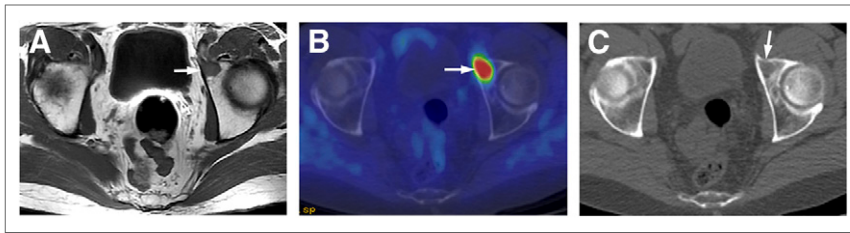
A 68-y-old man with PSA level of 5.0 ng/mL, who underwent RP 3 y earlier and then received salvage external-beam radiotherapy and androgen-deprivation therapy. Results for concordant true-positive MR imaging and ^{11}C -choline PET/CT results with a score for both MR imaging and ^{11}C -choline PET/CT of 5 for skeletal metastasis are shown. (A) Axial T1-weighted image shows 13-mm enhancing lesion in anterior left acetabulum (arrow). (B) ^{11}C -choline PET/CT image demonstrates corresponding choline-avid lesion (arrow) with SUVmax of 6.4. (C) Unenhanced CT scan of 7B shows subtle asymmetric lytic process (arrow).
